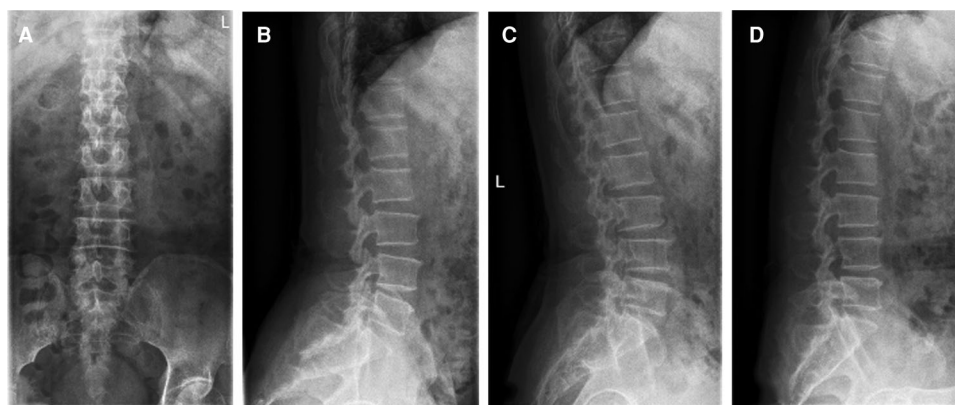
(A) The anteroposterior view of the radiograph shows no scoliosis. (B) The lateral view of the radiograph shows no spondylolisthesis. (C) The extension view of the radiograph shows no instability. (D) The flexion view of the radiograph shows no instability.
